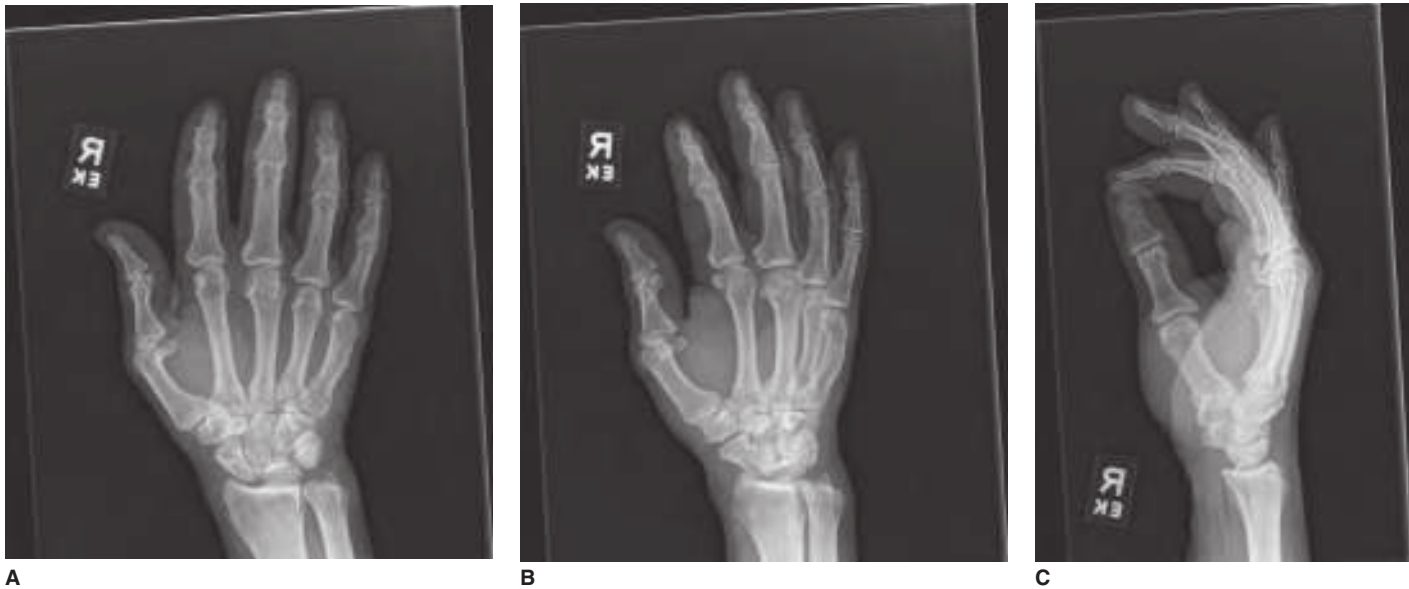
Plain radiographs of the hand. A. Anteroposterior view. B. Oblique view. C. Lateral view.
